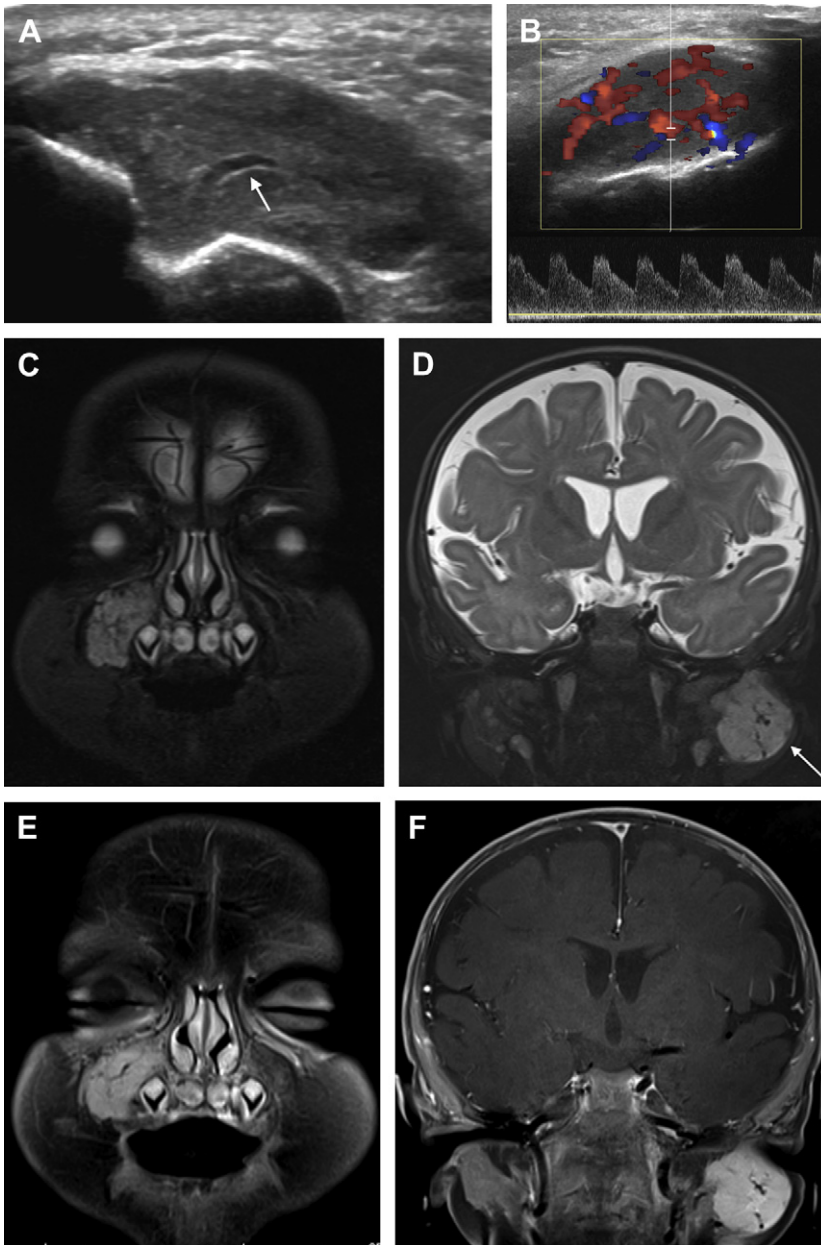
Infantile hemangiomas in a 3-month-old girl who presented with mass under her right eye. (A) Ultrasound image of the right face lesion demonstrates a well-defined mass in the subcutaneous tissues, abutting the underlying bone, with hypoechoic channels corresponding to vessels (*arrow*). (B) Color Doppler image confirms that the mass is hypervascular, with low-resistance arterial waveforms. MRI was performed at 4 months of age. Coronal STIR images again show the mass below the right eye (C) and a second IH involving the left parotid gland (D, *arrow*). Both are hyperintense on fluid-weighted sequence with dark flow voids corresponding to vessels. After intravenous contrast administration the IH of the right face (E) and left parotid (F) demonstrate homogenous enhancement.
